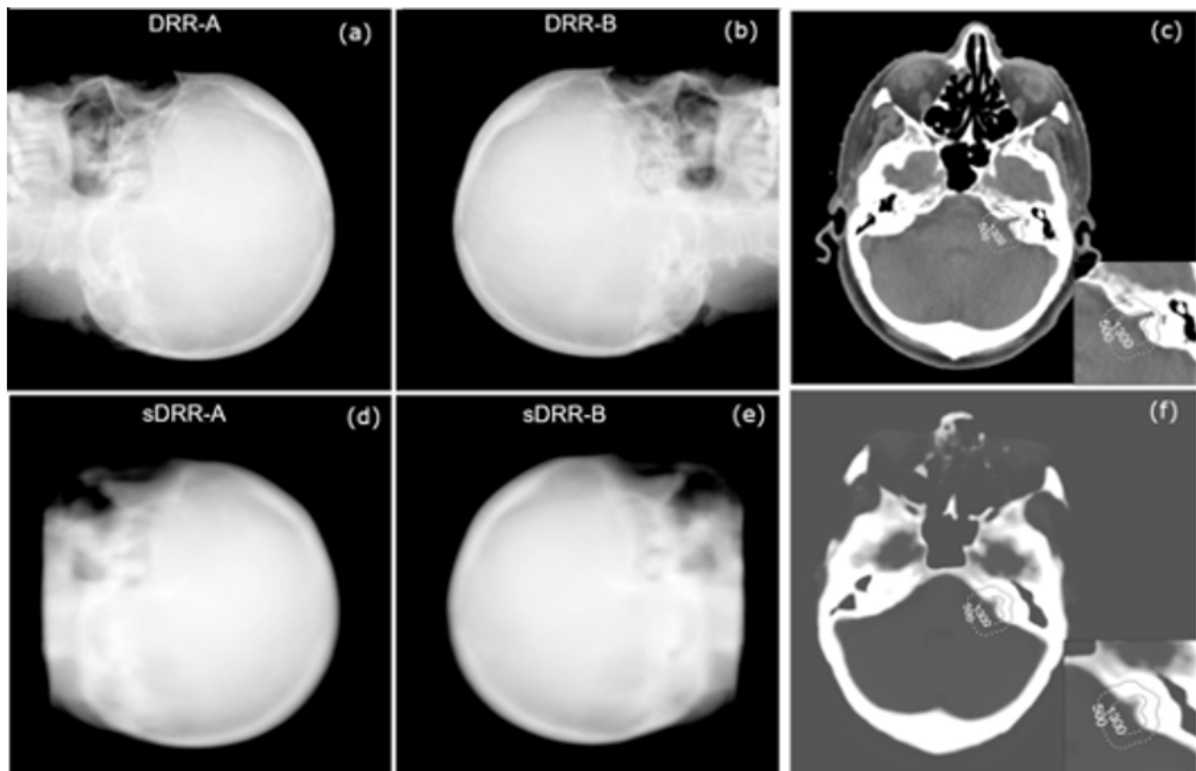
Digital reconstructed radiographs (DRRs) for the two projections (A, B) of the CyberKnife image guide system calculated using the CT (a, b) and the synthetic CT (d, e) for an indicative case. Axial CT (c) and sCT (f) slices depicting the dose distributions calculated using the CT (solid lines) and sCT (broken line) are also shown..
